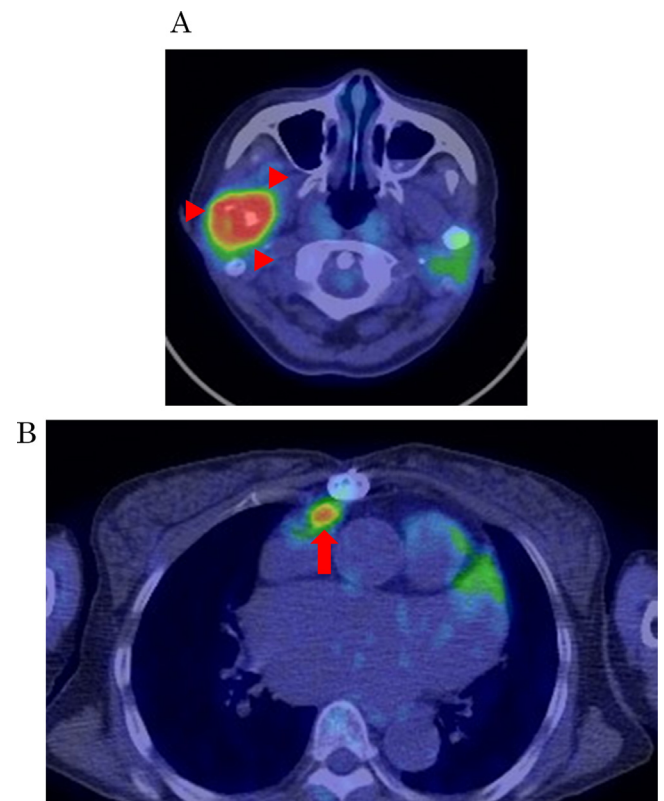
Findings of positron emission tomography with computed tomography using 18-fluoro-2-deoxyglucose. (A) The temporomandibular region exhibited significantly enhanced areas (indicated by red arrowheads). The maximum standard uptake value (SUV max) was 8.59. (B) The anterior mediastinum exhibited enhanced areas comparable to those observed in the mandibular condyle (indicated by red arrow). The SUV max was 4.98. (For interpretation of the references to color in this figure legend, the reader is referred to the web version of the article.)
